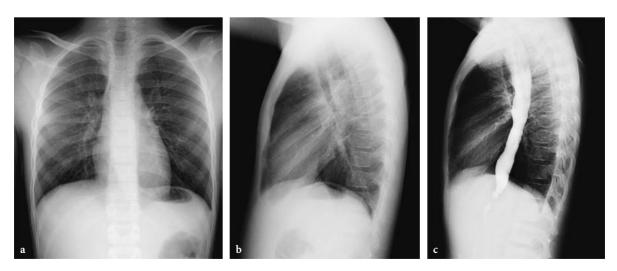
Achalasia. AP (a) and lateral (b) chest radiographs reveal an air-fluid level in the distended esophagus. c Delayed lateral chest radiograph. Barium fills the entire length of the esophagus, which tapers distally. There has been minimal flow of barium into the stomach
